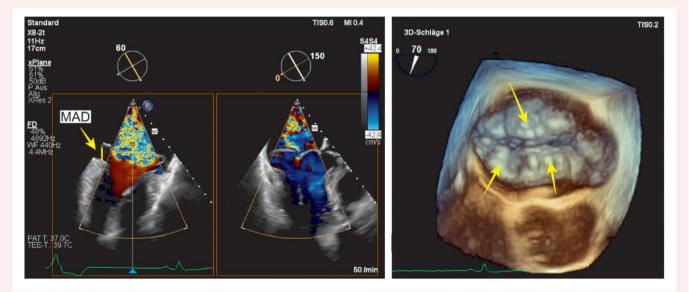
Transoesophageal echocardiography image showing mitral annular disjunction and mitral regurgitation (left image) as well as mitral valve prolapse (3D image on the right)—images used with kind permission from Dr Michael Mehr. MAD, mitral annular disjunction.
